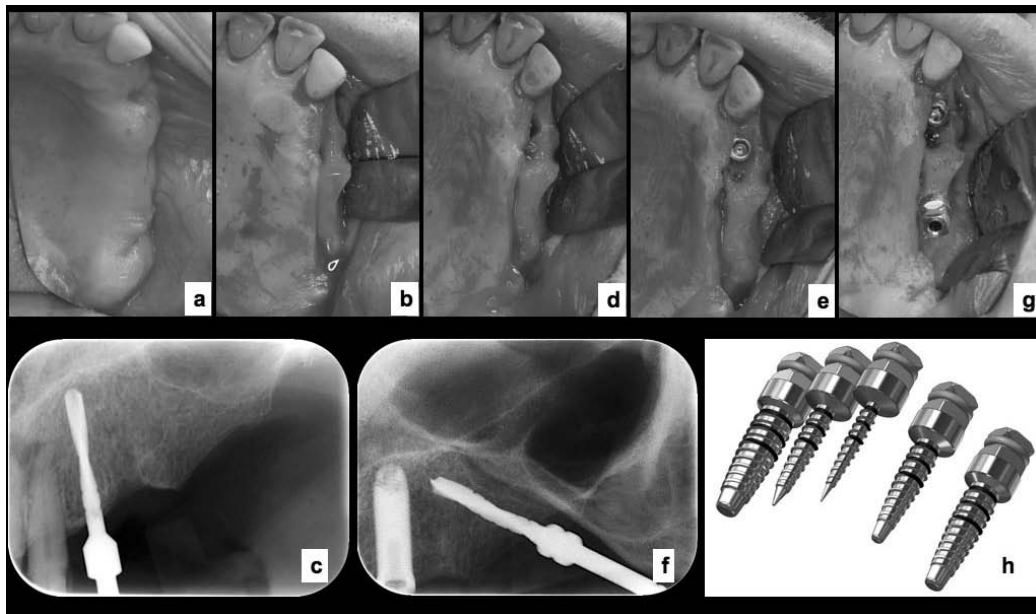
Clinical case describing the Tilted Implant Expansion Osteotomy (TIEO): *a)* intra-oral pre-operative condition; *b)* the full thickness flap is reflected; *c)* the bone bur is left “in situ” during radiographic evaluation of the future implant tunnel inclination; *d)* the anterior implant tunnel is prepared; *e)* the anterior implant is placed; *f)* radiographic evaluation of the position between the bone bur and the anterior sinus wall; *g)* the posterior implant tunnel is prepared by means of the tapered-screw bone expander (TSBE); *h)* the TSBEs.
